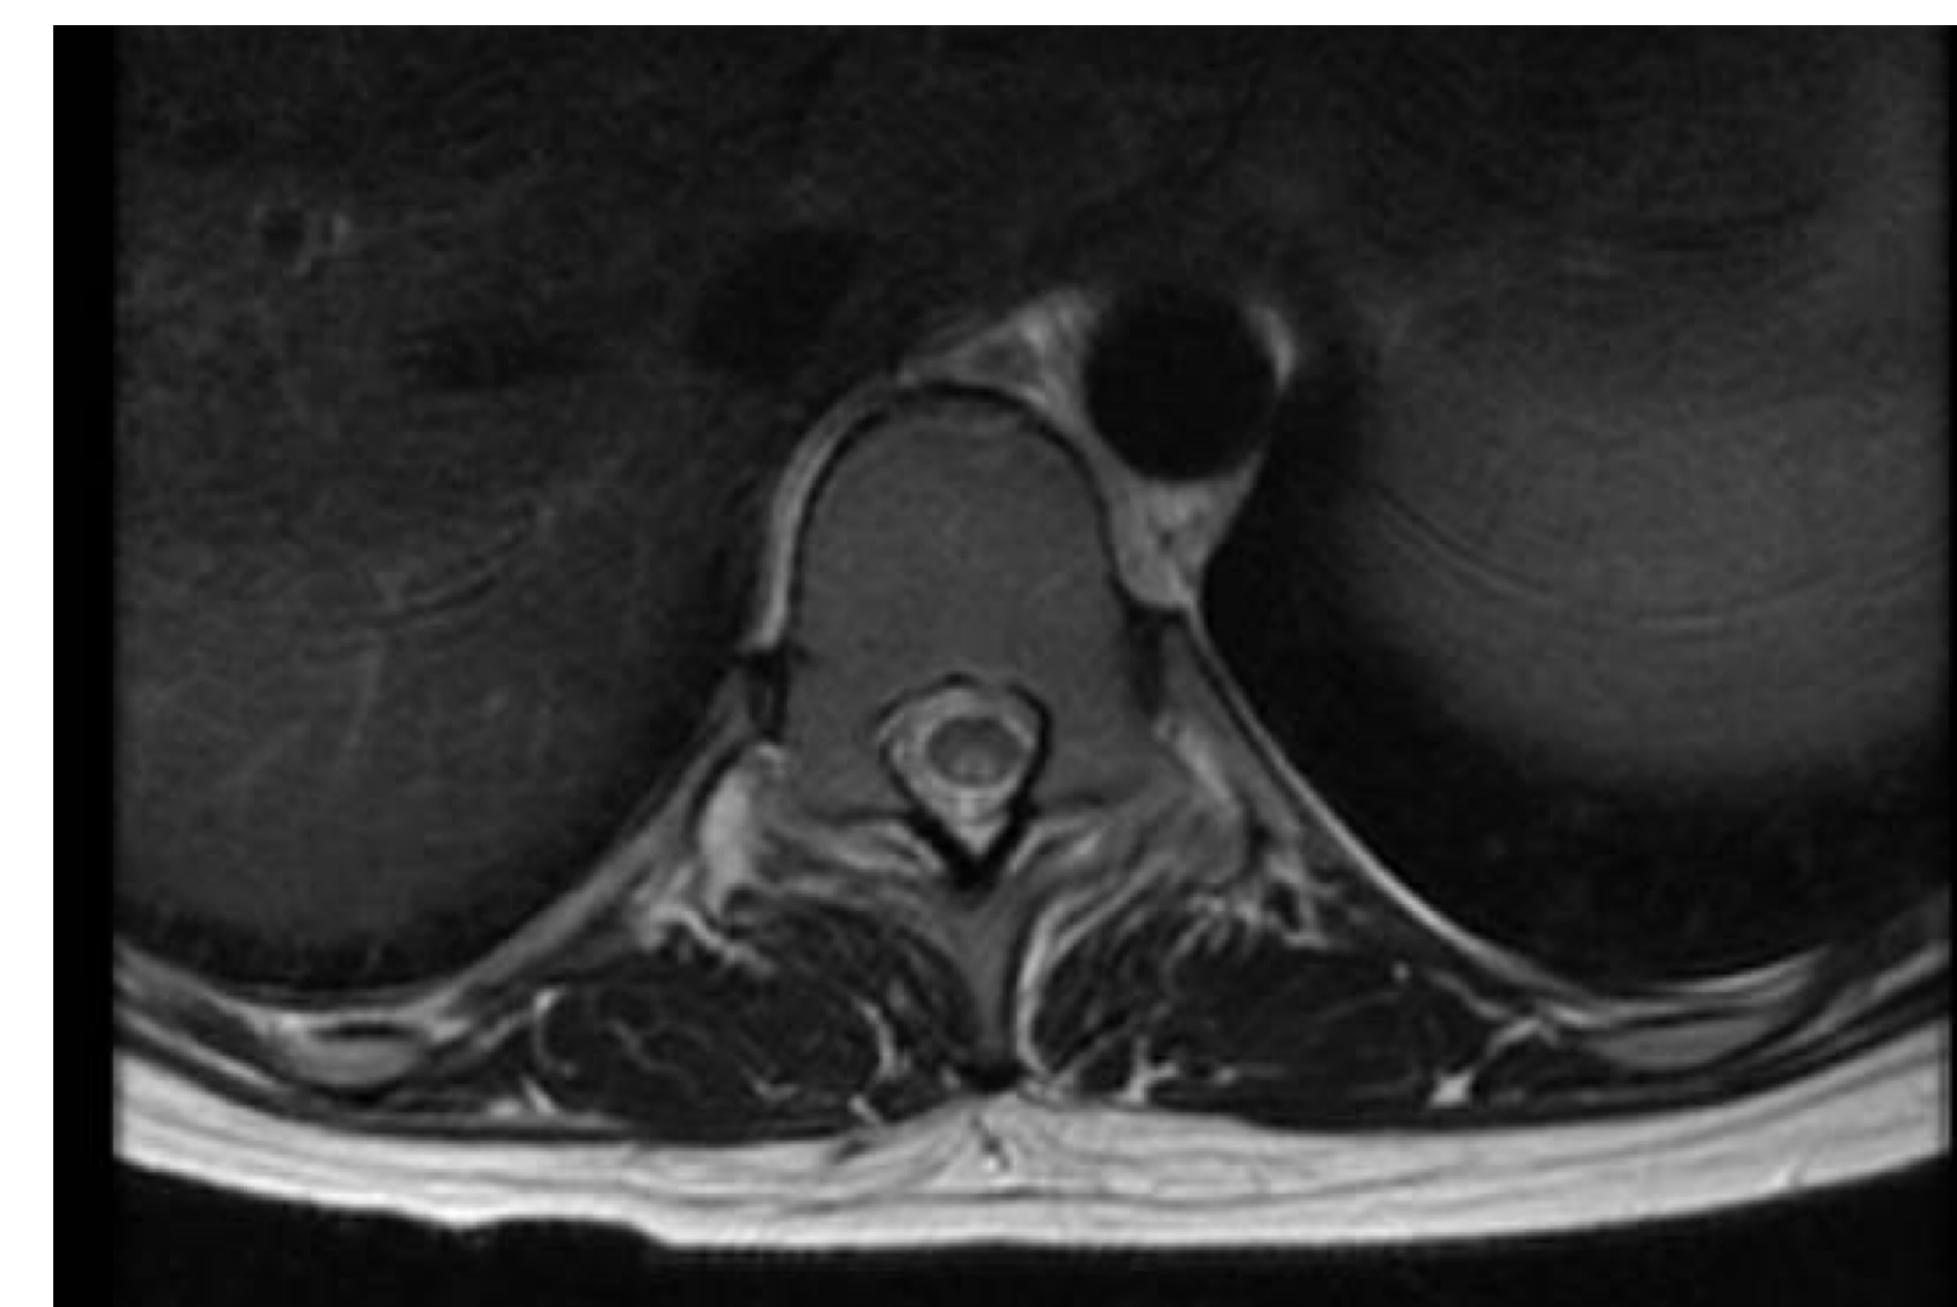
T2-weighted MRI of the thoracic spine showing enhancement of the dorsal columns at T10.
